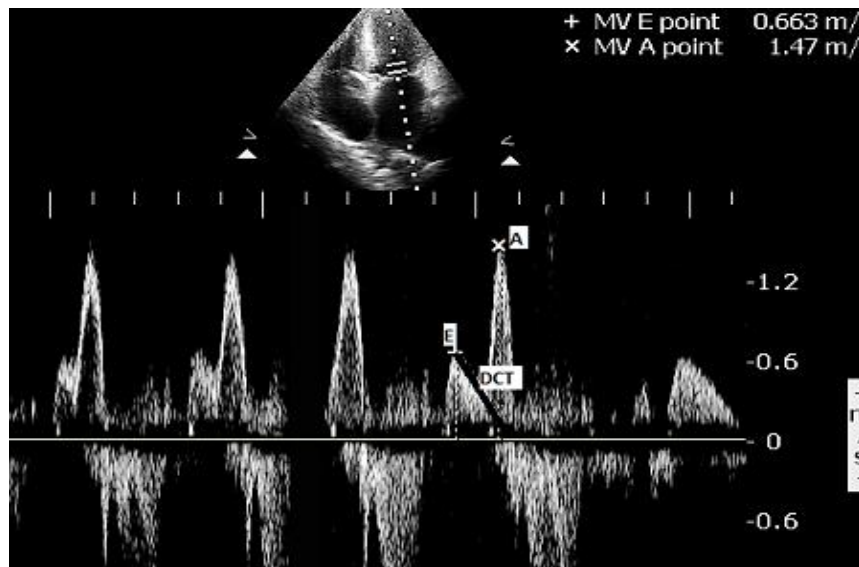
Pulse wave Doppler with mitral inflow pattern
